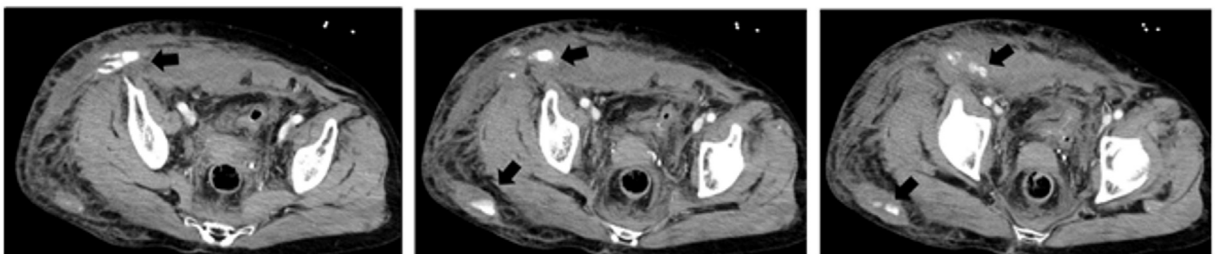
(a) The initial enhanced computed tomography (CT) scan shows slight subcutaneous hemorrhage of right groin area (arrow). (b) The other enhanced CT scan shows extravasation of both the right superficial circumflex iliac artery and right superficial epigastric artery, as well as the subcutaneous arteries of the gluteal (arrows).
